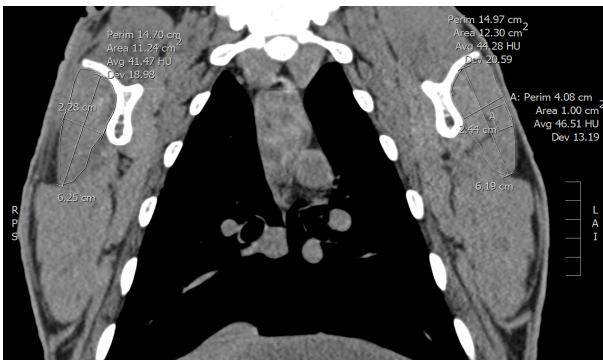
Coronal reconstructed CT image showing measurements of cross sectional area and density on both sides.
